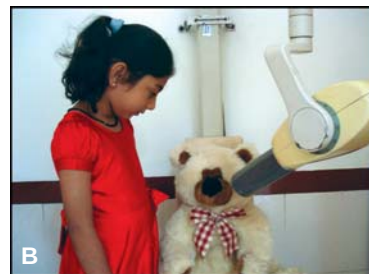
Tell Show Do (TSD) technique for preparing the child to be radiographed: A: The child is explained and the X-ray machine is compared to a camera; B: The X-ray tube is placed near doll's mouth; C: The X-ray is taken once the child is cooperative and ready
